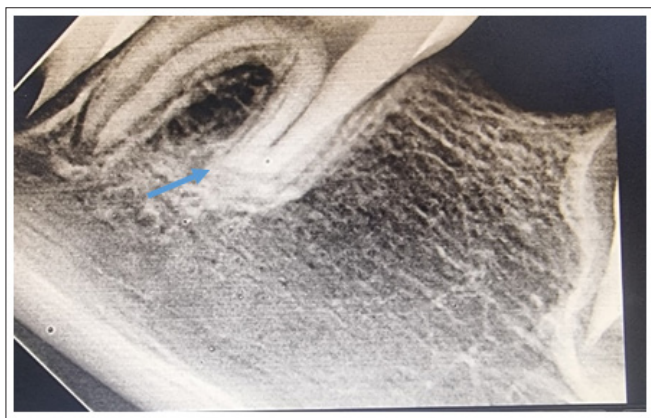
The Periapical X-Ray Demonstrated a complete Healing of the Lesion with Bone Regeneration. It Showed also the Arrest of Root development of the Mesial Root of the 46
